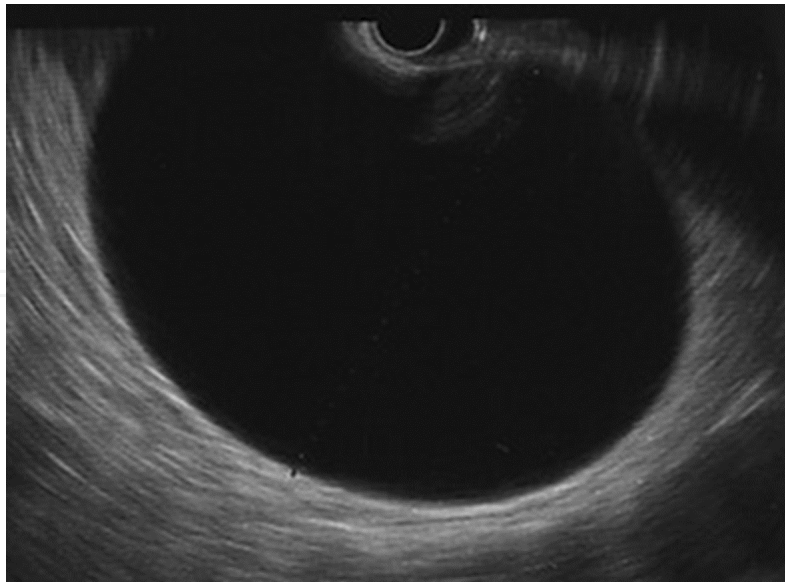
Picture of Pancreatic Pseudocyst by Linear Endoscopic Ultrasound (EUS)
